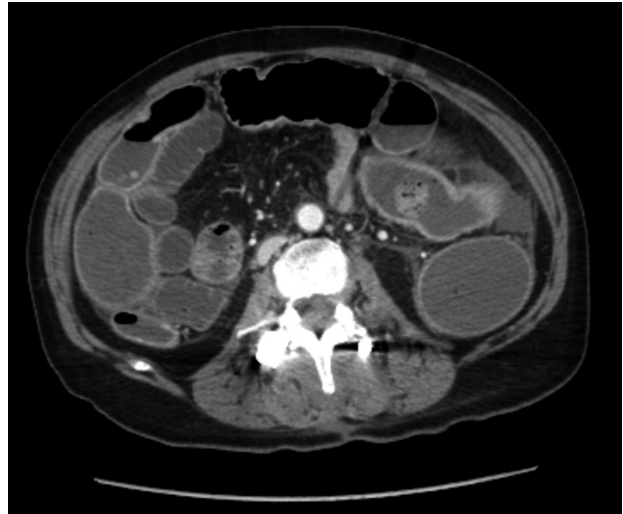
Post-STARR abdominal CT: signs of sigmoid ischemia.
